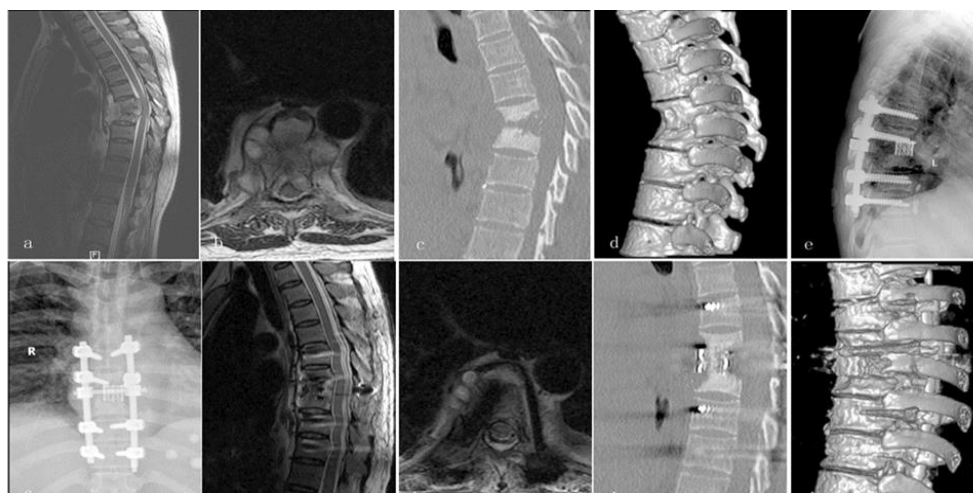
An internal fusion, titanium mesh cage, posterior-only debridement, and instrumentation were used to treat a 48-year-old female patient with thoracic TB (T7-T8). Preoperative kyphosis and degeneration of the T7-T8 spinal column were seen on preoperative MRI (a and b) and CT (e and d). At the last follow-up, radiography (e and f) demonstrated bone fusion that was definite and the correction was maintained. Complete decompression of the neural component and excellent bone fusion were observed in postoperative MRI (g and h) and CT (i and j).
